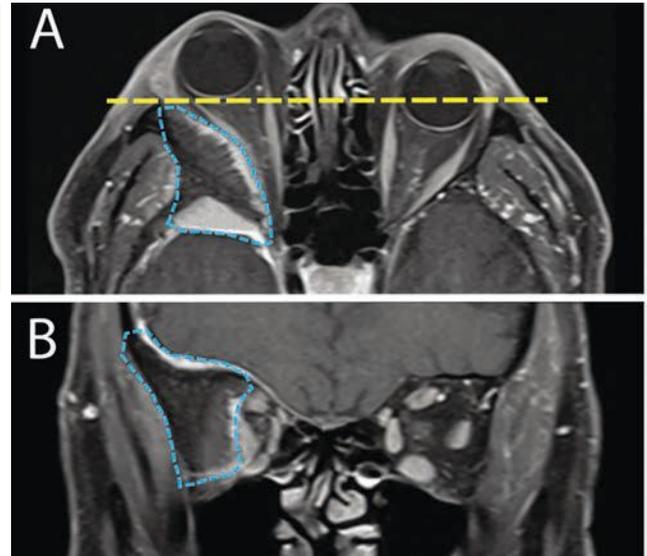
A: Axial MRI orbit study reveals a large intraosseous lesion of the greater wing of the sphenoid bone (blue line). The mass resulted in right globe proptosis (yellow line). B: Coronal MRI view reveals the extensive bony lesion (blue line) causing significant orbital volume loss and medialization of all orbital content.
